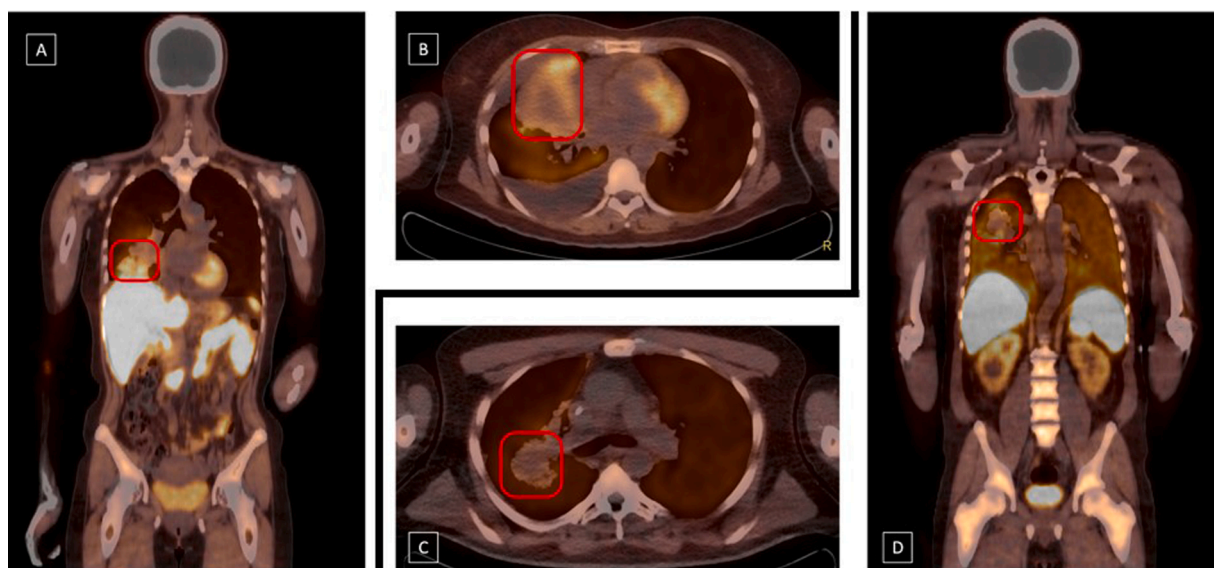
Typical PET/CT images of 2 NSCLC patients are shown. The coronal (A) and axial (B) PET/CT images of a 48-year-old female patient with an EGFR exon 19 deletion show an increased tracer tumor uptake, corresponding with a tumor TBR_{WB60-90} of 6.15. The tracer uptake is higher near the edges of the tumor, possibly due to central necrosis. This tumor responded well to afatinib therapy with a 60 % decrease of the largest tumor diameter. The axial (C) and coronal (D) PET/CT images of a 54-year old male patient with an EGFR wild type tumor. The tumor tracer uptake, as measured by TBR_{WB60-90} was 5.0. This tumor did not respond to afatinib treatment with 52 % increase of tumor diameter after 6 weeks.
